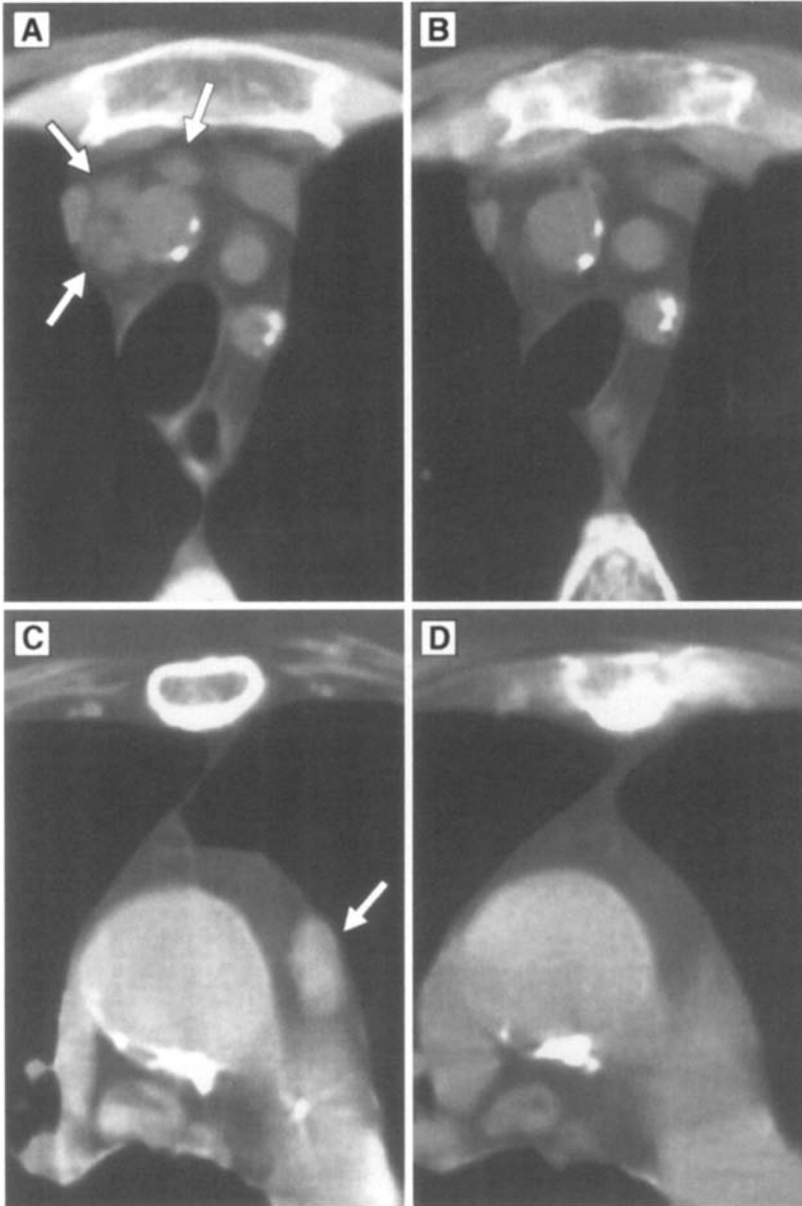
Computed tomography (CT) scan of the chest at the time of diagnosis (A, B) and 4 months after therapy with IFN- α (B, D) Note that mediastinal and para-aortic lymph nodes (arrows) resolved completely after treatment (taken from O'Brien et al. [38] with permission)
